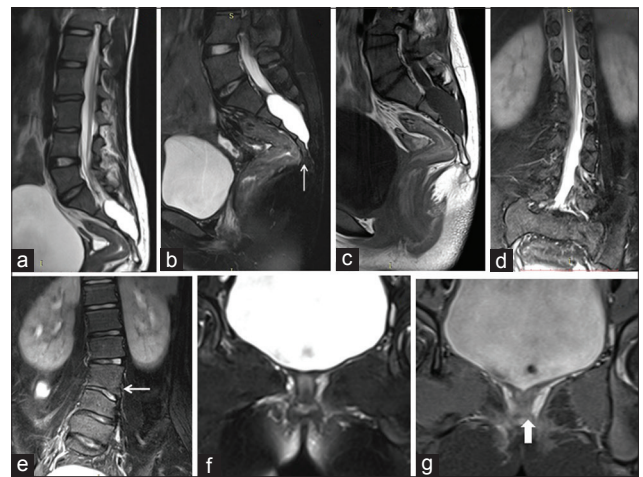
A 14-year-old female with primary amenorrhea. (a) Sagittal T2-weighted image, (b) short-tau inversion recovery, (c) T1-weighted images show a lobulated T1 hypo- and T2 hyper-intense intrasacral meningocele in the lower sacral spinal canal with the absence of coccyx and bilateral S5 segments of the sacrum (↑ arrow) representing Type III caudal regression syndrome. (d and e) Coronal short-tau inversion recovery images show L3 hemivertebra (← arrow) and low-lying spinal cord ended at L2 vertebral level. (f) Coronal fat-suppressed T2-weighted image and (g) coronal short-tau inversion recovery images show hypoplastic uterus (↑ block arrow) of Type I Mullerian anomaly.
